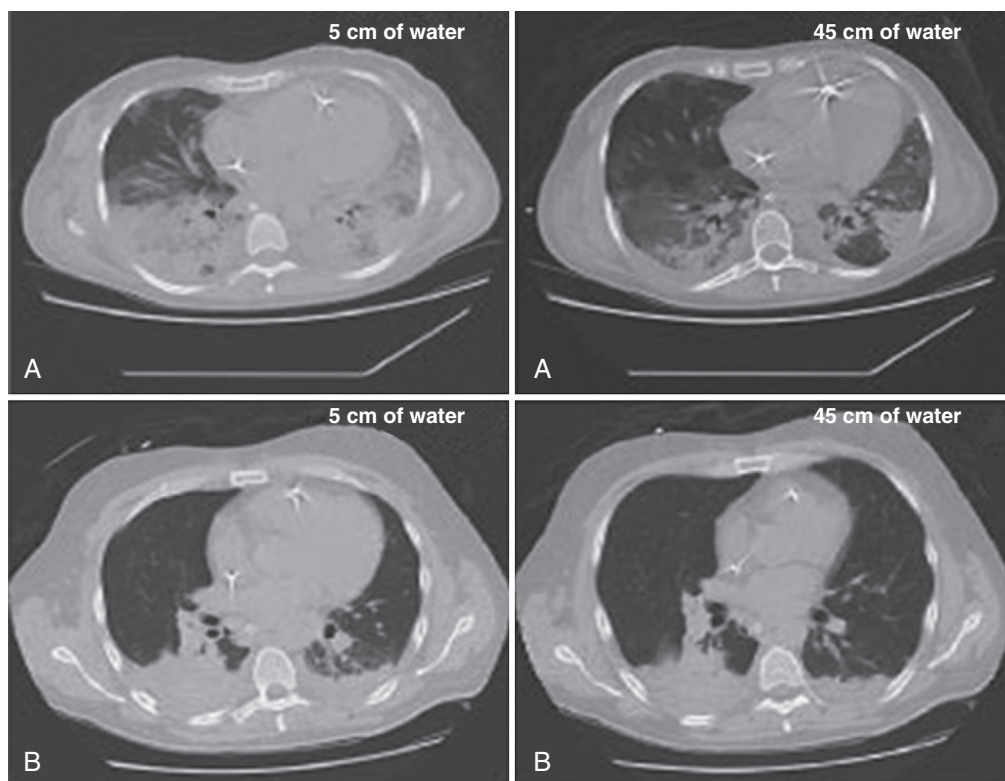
Computed tomography (CT) of the chest at low (5 cm H₂O) and high (45 cm H₂O) airway pressure in two patients with ARDS. A, Shifting of lung regions from poor to normal aeration suggests a significant potential for alveolar recruitment in this patient, who might benefit from increased levels of positive end-expiratory pressure (PEEP). B, High airway pressure only results in overdistention of previously aerated lung without achieving recruitment of poorly aerated lung tissue, suggesting that this patient may possibly not respond to high PEEP. (From Gattinoni L, Caironi P, Cressoni M, et al. Lung recruitment in patients with the acute respiratory distress syndrome. *N Engl J Med*. 2006;354:1775-1786.)
